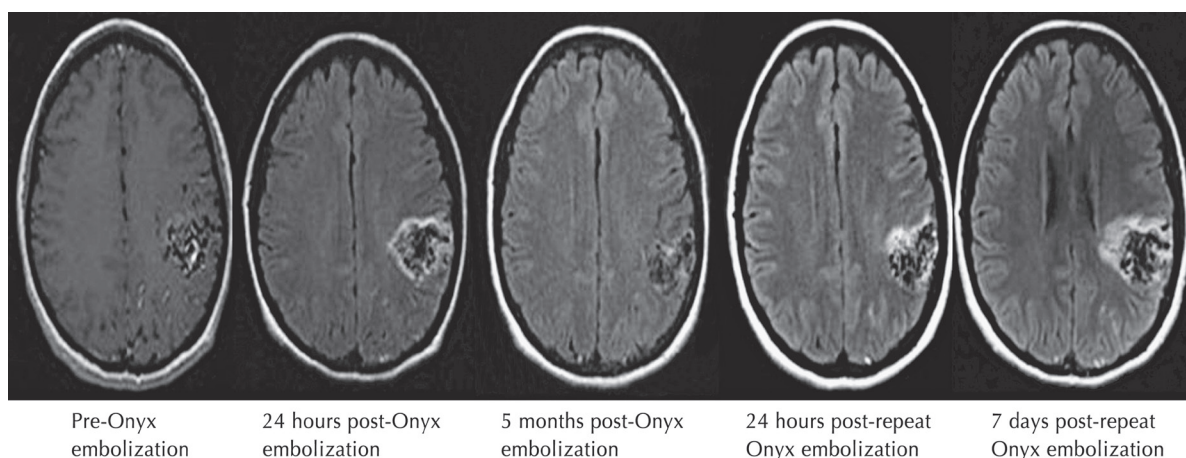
MRI T2 FLAIR axial sequences of left parietal AVM demonstrating increased FLAIR signal around the nidus following the first and repeat Onyx embolization, as well interval resolution of flair signal 5 months after the first embolization. This patient developed seizures after both Onyx embolizations.
